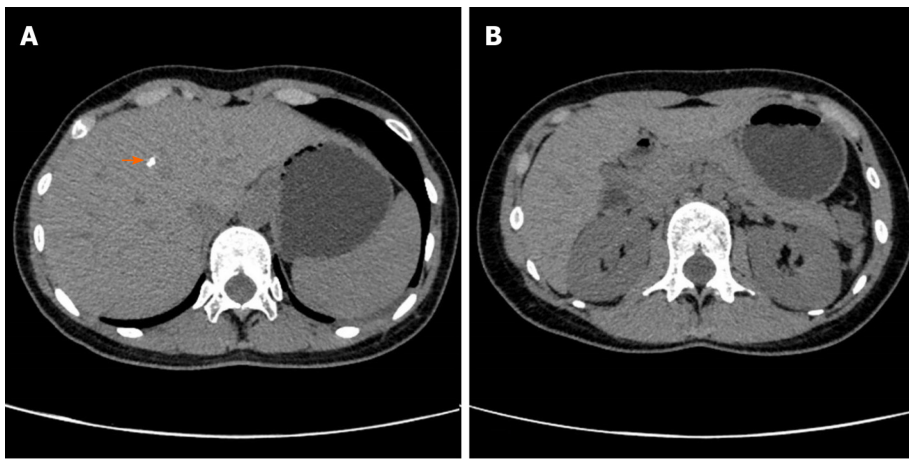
Abdominal computed tomography. A: Dotted high-density shadow (orange arrow) on the right liver; B: No abnormal occupation was captured in the kidneys.
